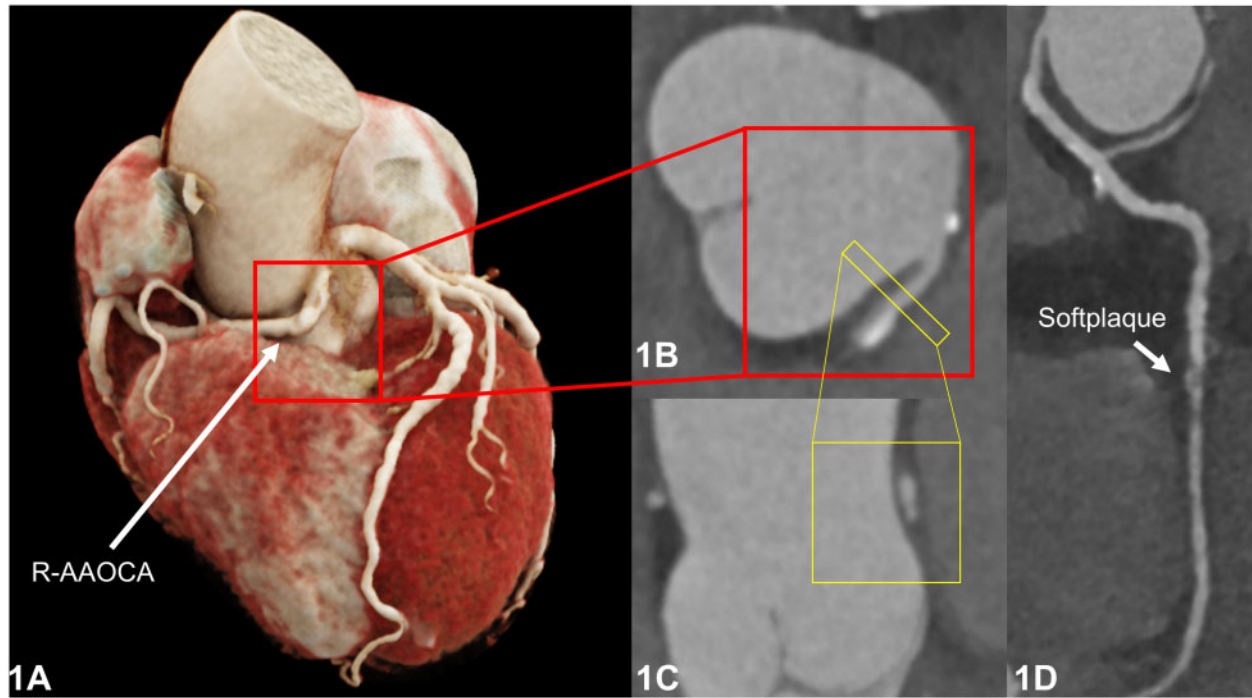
(A) Coronary computed tomography angiography of the right anomalous aortic origin of the coronary artery. (B) Interarterial course. (C) The elliptic proximal vessel shape (cross section with an increased height to width ratio) is depicted and is an indirect sign of the intramural course. (D) Right anomalous aortic origin of the coronary artery with softplaque in the distal part. Please note the other anatomical 'high-risk' features as acute take-off angle (B), proximal narrowing (C and D), and the oval vessel shape (C).
